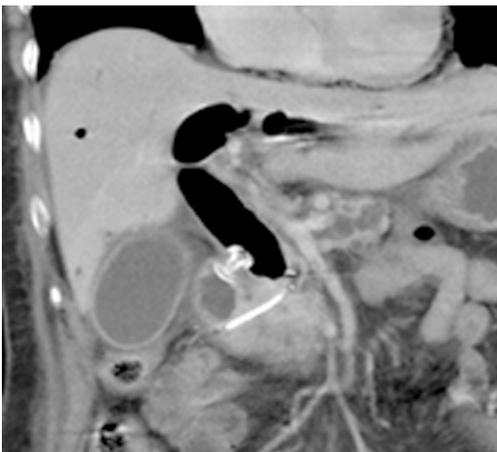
Computed tomography scan appearance of electrocautery-enhanced lumen-apposing metal stent deployed across the duodenal bulb and plastic pancreatic stent previously placed during failed endoscopic retrograde cholangiopancreatography.
